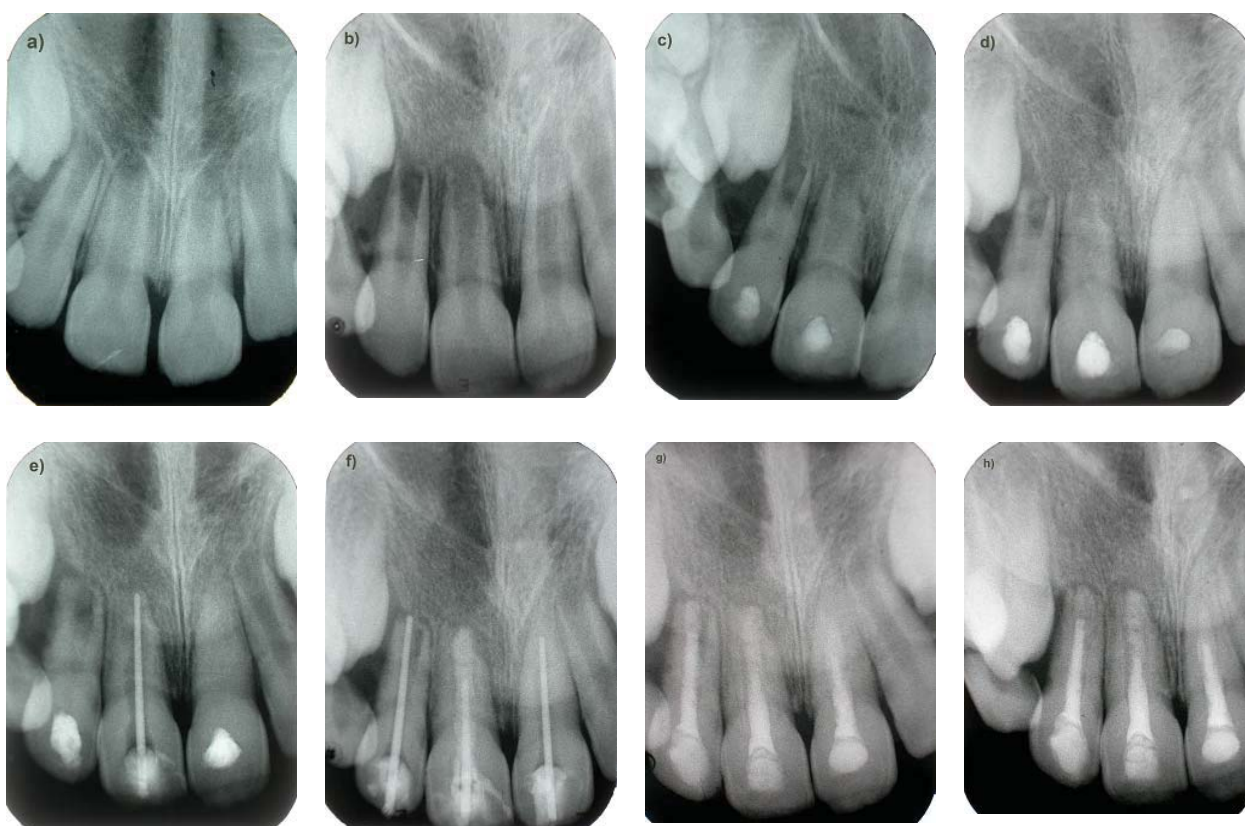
a) Radiographic view immediately after trauma; b) Radiographic view after 2 months; c) View after 4 months, calcium hydroxide dressing; d) Radiographic view after 6 months calcium hydroxide dressing; e) Odontometry of the tooth 11; f) Odontometry of the teeth 12, 21; placement of MTA in the apical third of the tooth 11; g) Definitive obturation with MTA, root canal sealer and gutta-percha; h) Radiographic follow-up after 6 months.
